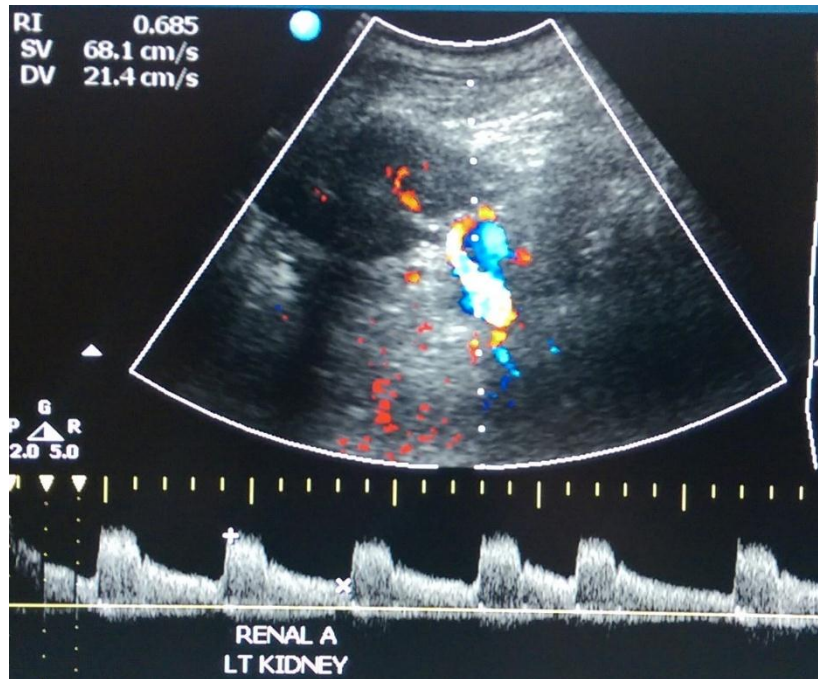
Doppler ultrasound image of the right renal artery showing blunting of the upstroke but a normal RI.
